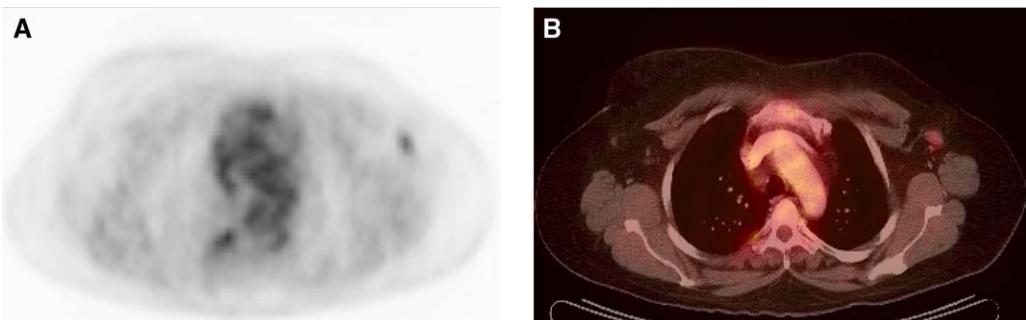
Frontal maximum-intensity projection PET image (A) and sagittal slices from a PET/CT scan (B) show a mammographically occult 8-mm breast cancer detected incidentally by FDG-PET during a workup for presumed recurrent breast cancer in a patient with rising carcinoembryonic antigen. An ultrasound guided biopsy demonstrated an invasive ductal carcinoma, which was resected with clear margins.
